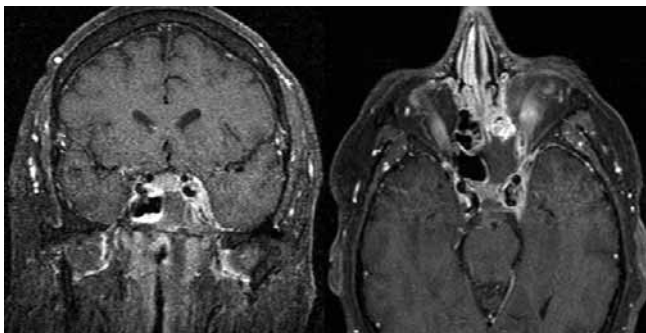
T1 weighted post gadolinium enhanced MRI of the brain showing left sphenoid sinusitis with adjacent dural enhancement. Axial view reveals enhancement of cavernous sinus.
